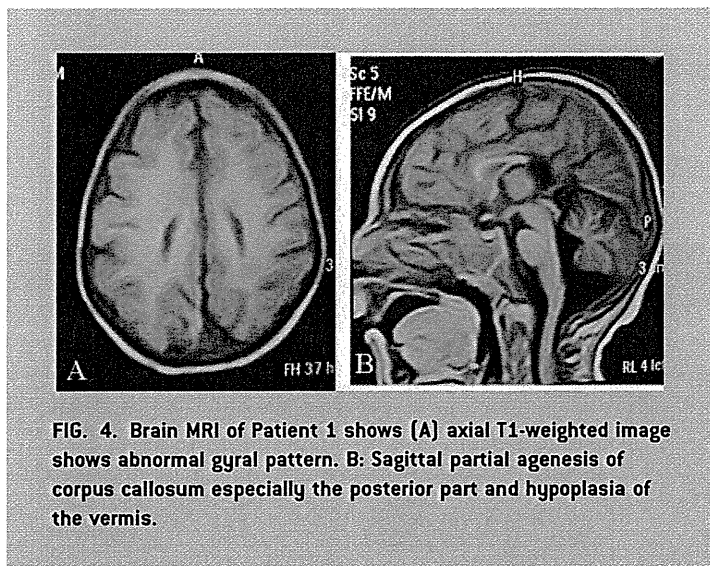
Brain MRI of Patient 1 shows (A) axial T1-weighted image shows abnormal gyral pattern. B: Sagittal partial agenesis of corpus callosum especially the posterior part and hypoplasia of the vermis.
